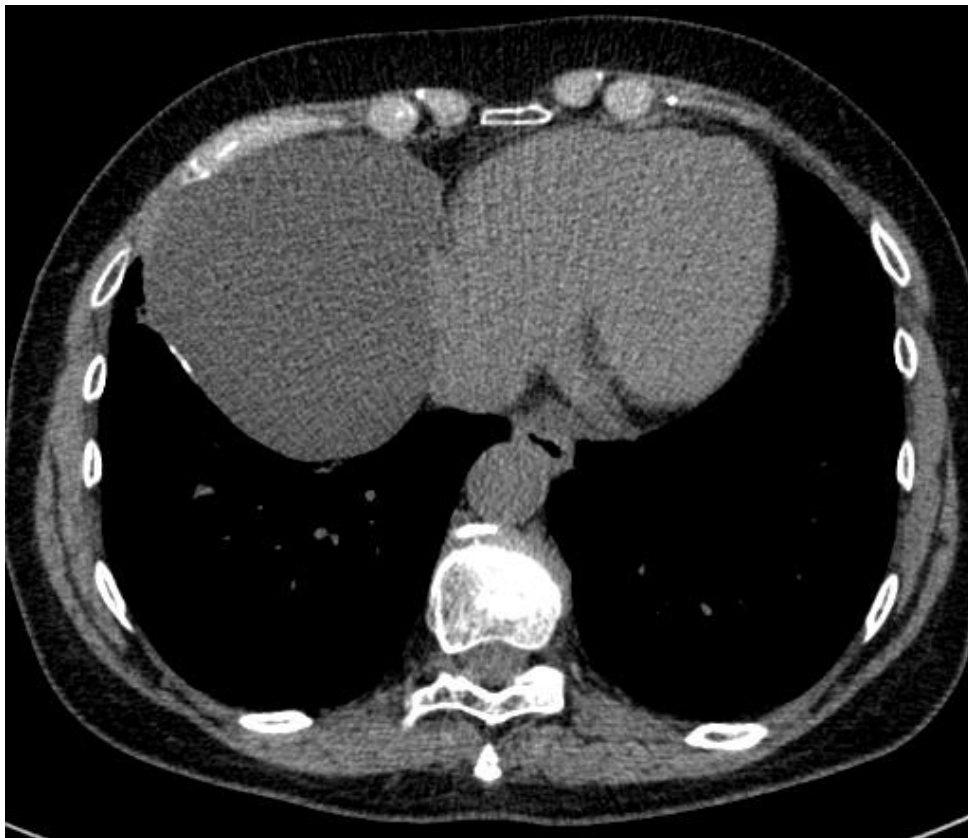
CT MPR axial view showing a pericardial cyst compressing the right atrium.
